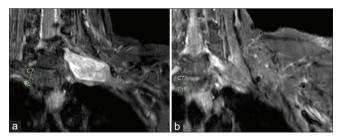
Preoperative magnetic resonance imaging (MRI) showing an enhancing 5-cm mass at the levels of C6-T1 with proximal extension toward the C7 foramen (a). Postoperative MRI 3 months after surgery shows near total resection of the lesion (b).
